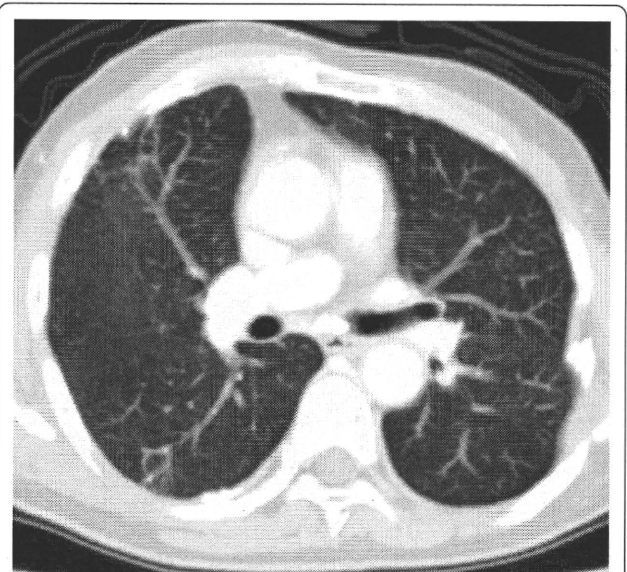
CT images before SBRT (Pt. No. 8).
